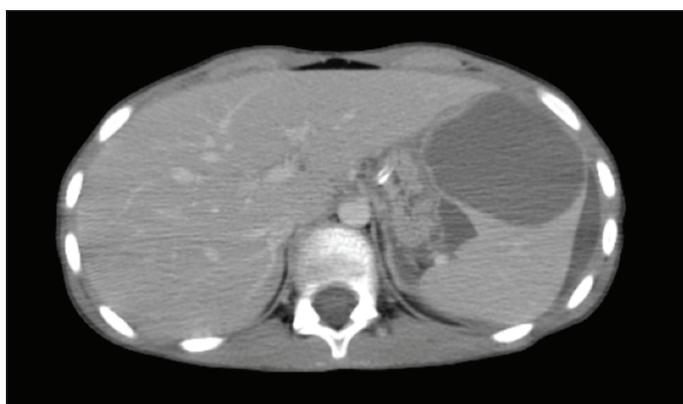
Abdominal computed tomography sections showing a cystic lesion anterior upper pole of the spleen.
